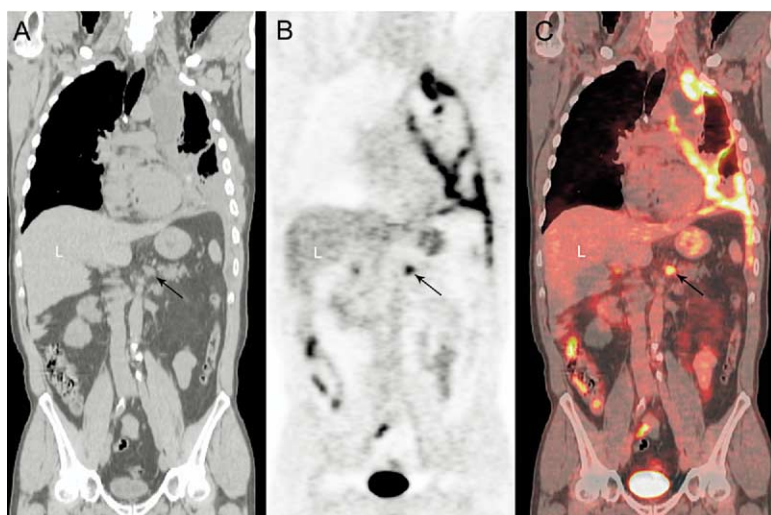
Coronal computed tomography (CT) (A), positron emission tomography (PET) (B), and integrated CT-PET (C) show diffuse uptake of [^{18}F]-fluoro-2-deoxy-D-glucose (FDG) in primary left pleural tumor and focal area of increased uptake in the abdomen (arrow) localized to an abdominal lymph node. Biopsy confirmed nodal metastasis, precluding patient from extrapleural pneumonectomy (EPP). L, Liver.
